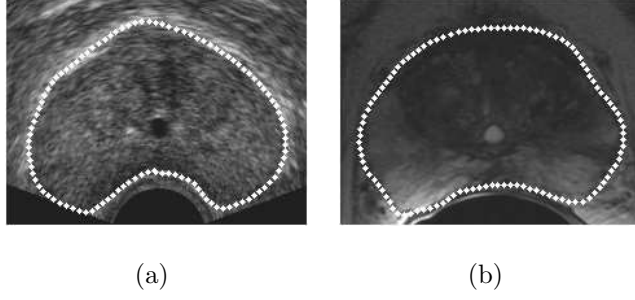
Uniformly sampled contours. (a) and (b) are the uniformly sampled segmented prostate contours on the TRUS and MR images respectively.
